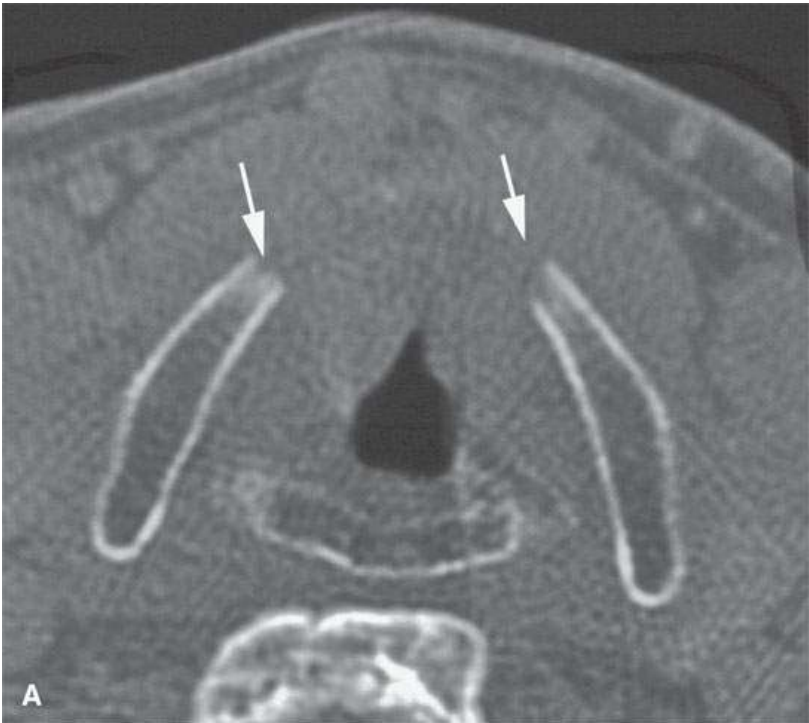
A patient with nasopharyngeal squamous cell carcinoma. A, B: Computed tomography showing marked reactive bony changes (*arrows*) in the central skull base due to adjacent and/or infiltrating tumor. C–E: Three-dimensional contrast-enhanced T1-weighted gradient echo images showing the thickened sclerotic bone with subtle evidence of marrow space enhancement (*arrow heads*) due to tumor infiltration and/or reactive changes.
